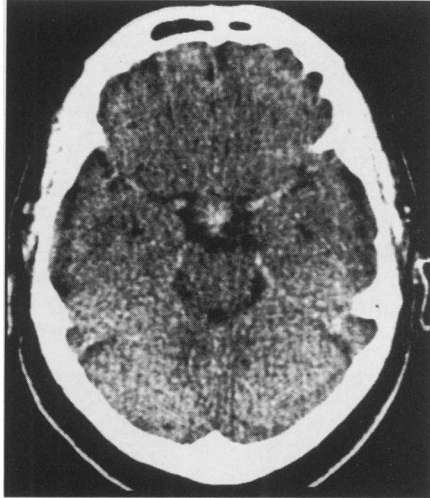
Axial CT scan of brain
